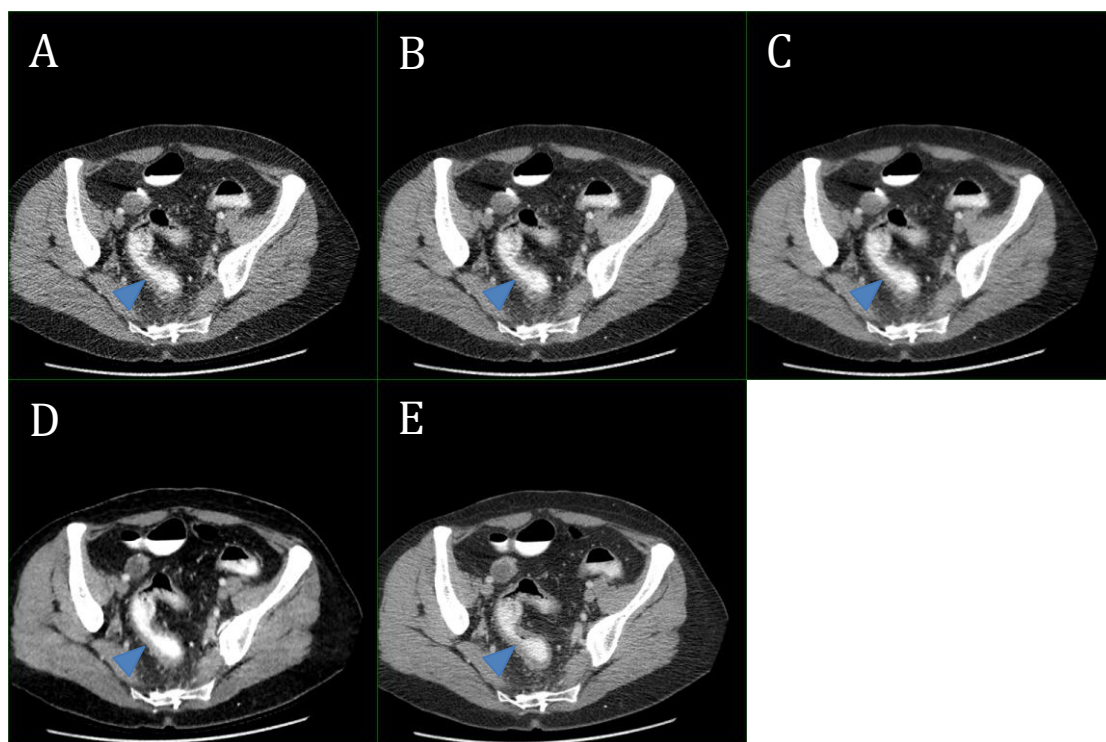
(A-E): Axial reconstructions of modified dose CT images with FBP (A), ASiR 40% (B), ASiR 70% (C) and MBIR (D) with conventional dose CT with FBP for comparison (E). Images depict active Crohn's colitis of the sigmoid colon with local mesenteric fat stranding and vascular injection (blue arrowhead) in a 43 year old lady with a BMI of 24.2 kg/m². The modified dose CT was acquired at 1mSV and the conventional dose CT at 4mSV.
